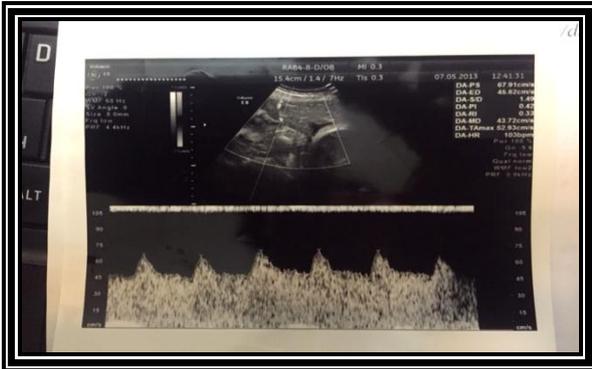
Dopplerometry. Blood flow in the right uterine artery (IR-0.33).
